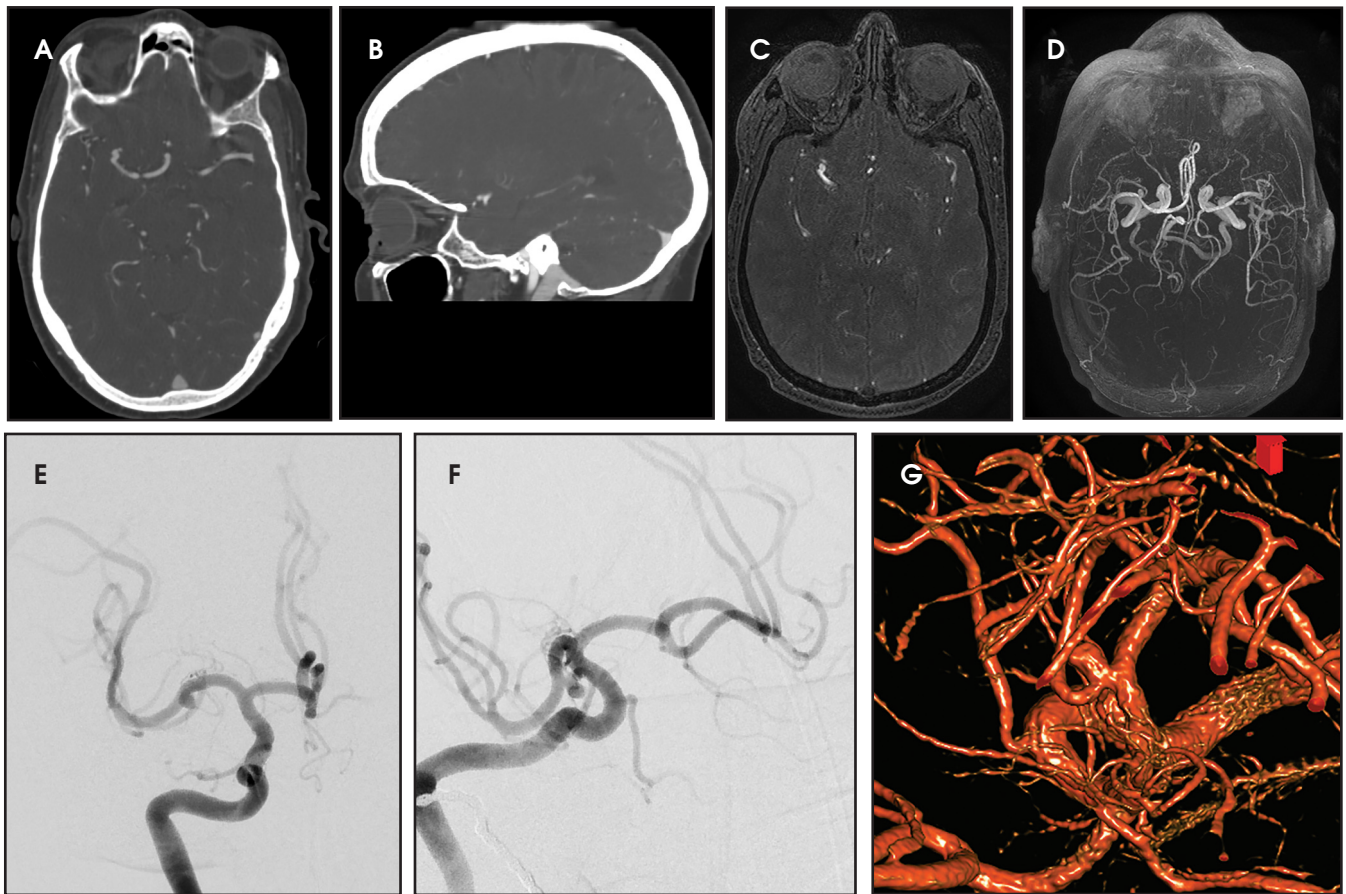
(A, B) Saccular aneurysm of the right MCA demonstrated on CTA (C, D). MRA, (E, F) and DSA. (G) More detailed visualization of the aneurysm is provided with three-dimensional reconstruction.
